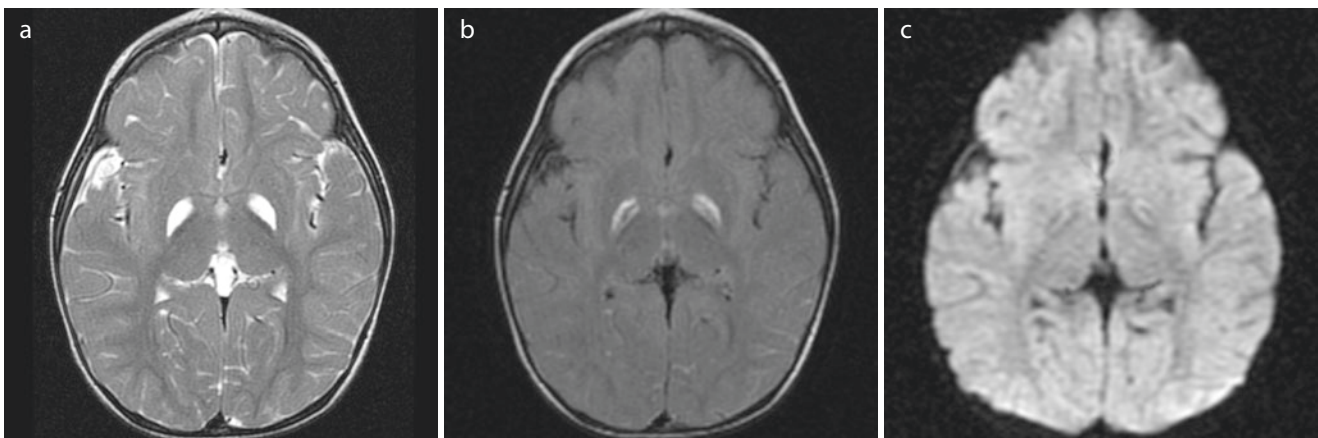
A 15-year-old female with methylmalonic aciduria. (a) Axial T2WI (TR/TE msec, 4217/101) through the basal ganglia shows hyperintense globi pallidi. The corresponding T2/FLAIR sequence (TR/TE/ TI msec, 10,000/136/2200) (b) and diffusion-weighted sequence (TR/
